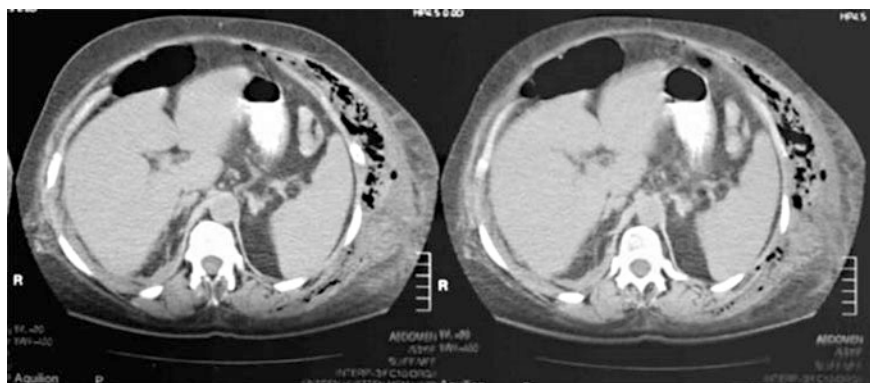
CT scan showing extensive gas gangrene of the left flank and entire chest wall. © Dale Dangleben, MD
